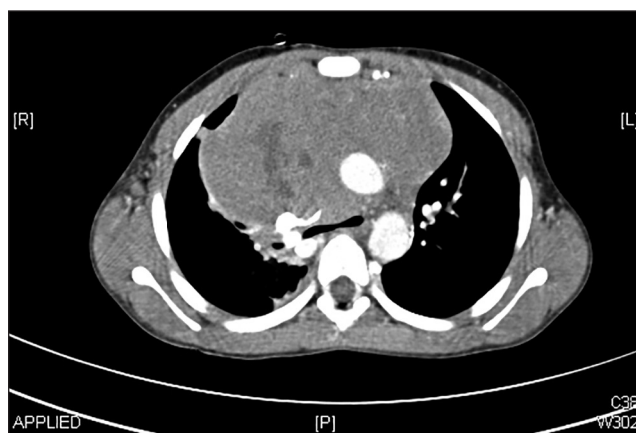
Computed tomography scan (thorax) depicting area of maximal compression of the trachea by the mediastinal mass
